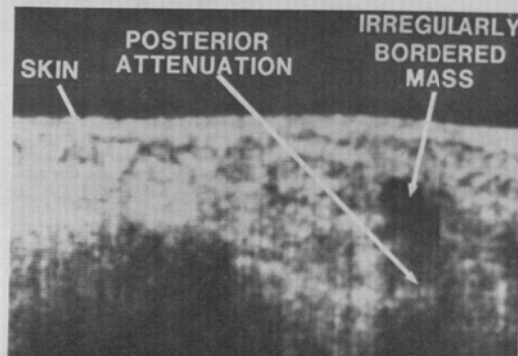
Ultrasound image of infiltrating duct carcinoma in breast of a 57-year-old patient. Above photo demonstrates marked irregularity of the wall of the mass. Photo below shows the acoustic shadowing posterior to the mass.
